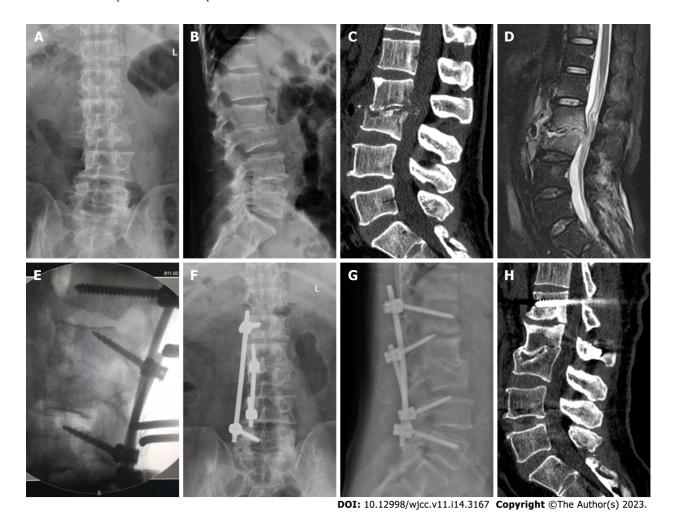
A typical case with bone fusion. A 47-year-old male patient presented with low back pain and left leg numbness and weakness. A and B: The pathological diagnosis was L2/3 lumbar tuberculosis, preoperative lumbar spinal X-ray showed L2/3 intervertebral space collapse; C: Lumbar spinal CT showed L2/3 intervertebral space stenosis and vertebral body destruction, and sequestrum could be seen invading the front of the intervertebral space and protruding backwards into the spinal canal; D: Fat-suppressed magnetic resonance imaging of the lumbar vertebrae showed destruction of the L2/3 intervertebral disc, narrowing of the intervertebral space, pus formation in the intervertebral space protruding towards the front and back of the intervertebral space, and compression of the dural sac; E: C-arm fluoroscopy during the operation confirmed good positioning of the pedicle screws and cortical bone trajectory screws; F and G: X-ray of the lumbar spine 1 year after the operation showed L2/3 intervertebral space fusion, normal positioning of the internal fixation device, and the absence of broken screws and rods; and H: CT scan of the lumbar spine 1 year after the operation showed that the L2/3 vertebral bodies had fused and that tuberculosis lesions had not developed. CT: Computed tomography.
